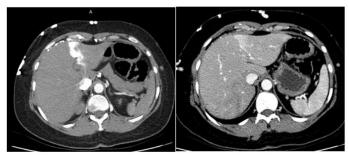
Axial views Contrast enhanced CT arterial (a) and portal (b) phase, showed the area of intense focal enhancement) in segment IV of liver that represents hepatic hot spot sign
